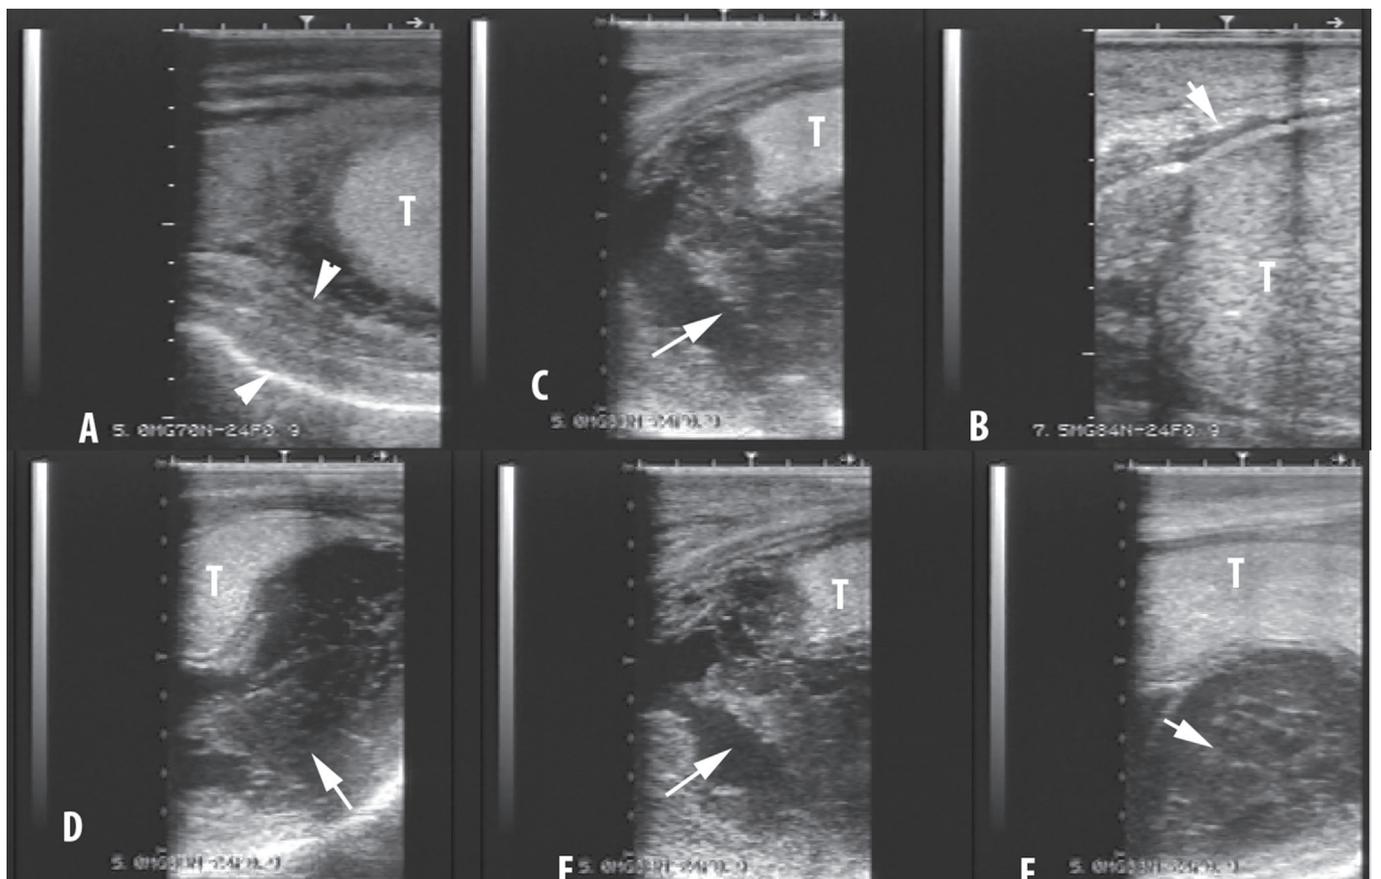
Ultrasonogram of a ram testis with severe orchitis and periorchitis. A- Arrows denote the thickened testicular envelopes. B) Arrows denote the presence of pus in the vaginal tunic. C-F) arrow shows testicular abscess (T= testicular parenchyma)
